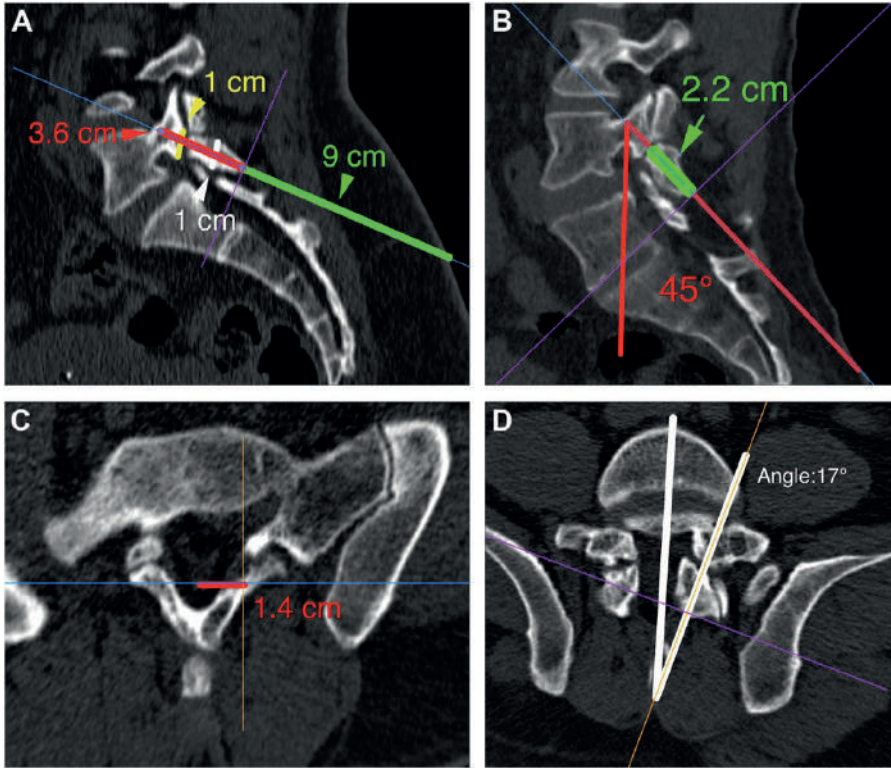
(A) Linear values for the ideal intralaminar screw trajectory in the lumbar 5 vertebrae (L5) lamina in the sagittal plane. Intralaminar screw length 3.6 cm, pars defect neck diameter 1 cm, midlamina thickness 1 cm, skin-to-lamina distance 9 cm (B) Sagittal angle (45°) and isthmic lamina length (2.2 cm) of the ideal screw trajectory relative to the posterior cortex of the vertebral corpus on computed tomography in the sagittal plane. (C) Distance of the screw insertion site from the line passing through the middle of the spinous process on computed tomography in the axial plane. (D) Trajectory of the coronal angle between the midspinous line and the screw trajectory line.
